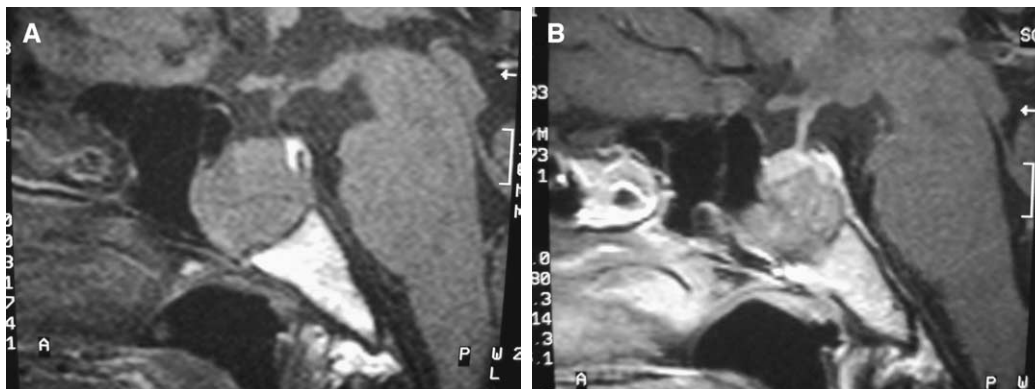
Macroadenoma with infrasellar location. (A) Sagittal T1-weighted image shows a large mass in the infrasellar location. The normal pituitary is seen at the superior aspect of the mass. (B) Sagittal postcontrast T1-weighted image demonstrates the mass in an infrasellar sphenoid sinus location. The normal pituitary is seen at the superior aspect of the mass and shows slightly more intense enhancement compared with the macroadenoma.
